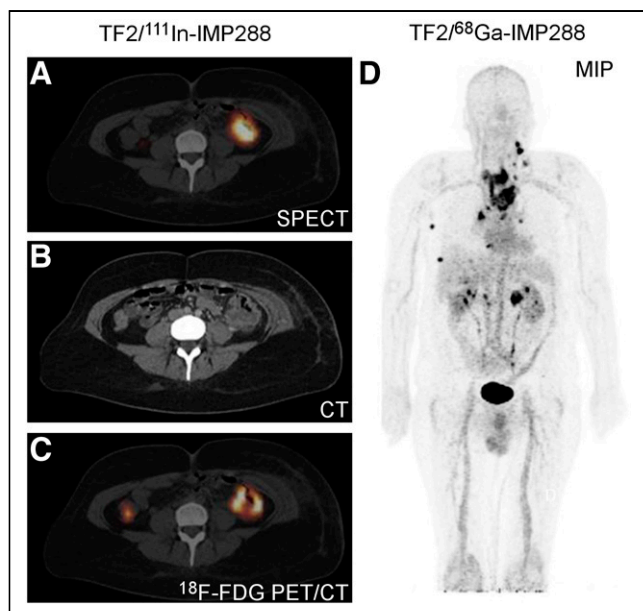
Select examples of recent clinical BsAb PRIT with DNL TF2 and radiolabeled IMP288 (TF2/IMP288). (A) Scintigraphic images (axial views) of CRC patient imaged with TF2/¹¹¹In-IMP288, with highly specific targeting of primary colon tumor, confirmed by CT and ¹⁸F-FDG PET/CT (B and C, respectively). (Reprinted from (108).) (D) PET image (coronal view) of MTC patient imaged with TF2/⁶⁸Ga-IMP288, with maximum-intensity-projection (MIP) image showing several pathologic lesions. (Reprinted from (115).)
